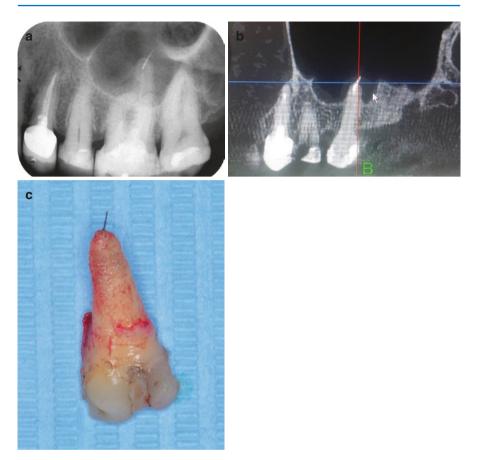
(a) Preoperative radiograph of a maxillary left second molar with an inadequate root canal treatment and a fragment in the palatal root extruding beyond the foramen into the sinus in a 75-year-old patient with compromised general health. (b) CBCT image shows characteristic thickening of the inner lining (mucosa) of the sinus. (c) Palatal root of the extracted tooth
